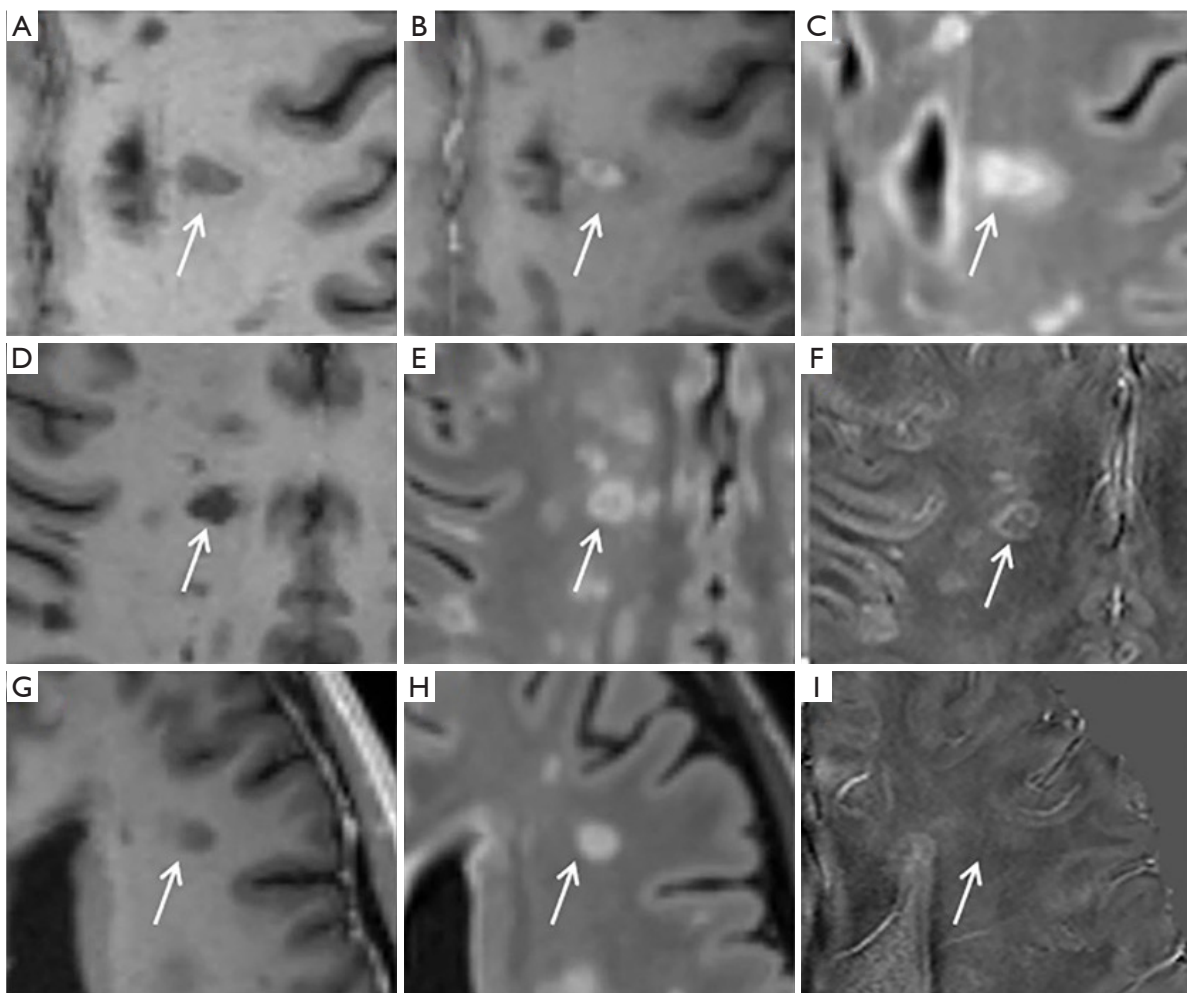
Example of three types of lesions. CELs show hypointense in pre-contrast T1 (A), enhancement in post-contrast (B), and hyperintense in T2-FLAIR (C). The IRL displays T1 hypointense (D), T2-FLAIR hyperintense (E), and hyperintense iron ring on QSM (F). NIRLs appear hypointense on T1 (G), T2-FLAIR hyperintense (H), and isointense on QSM (I). The white arrows point to lesions at the same location of different sequences. CELs, contrast enhancement lesions; T2-FLAIR, T2-fluid-attenuated inversion recovery; IRL, iron rim lesion; NIRLs, non-iron rim lesions; QSM, quantitative susceptibility mapping.
